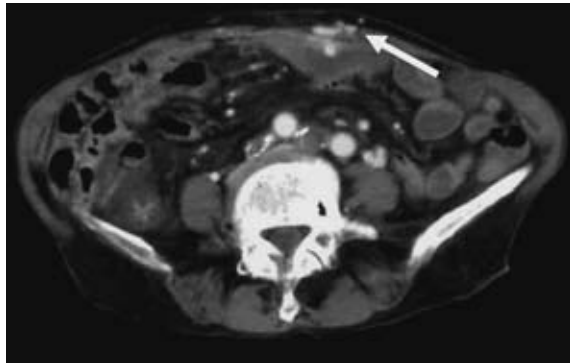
Ileal varices (arrow) were detected using abdominal computed tomography.
